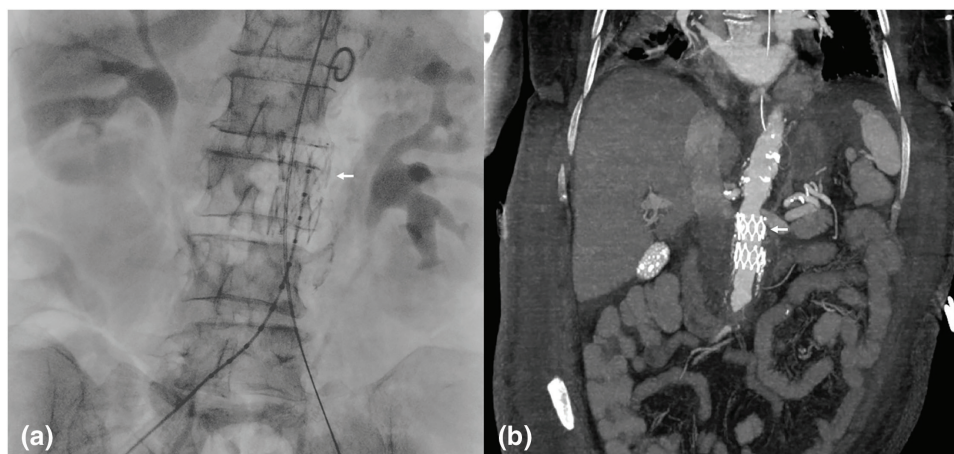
Angiography (a) and computed tomography angiography (CTA) with maximum intensity projection (MIP) reconstructions in the coronal plane (b) in the immediate postoperative follow-up after Zenith Cook cuff placement (white arrows).
